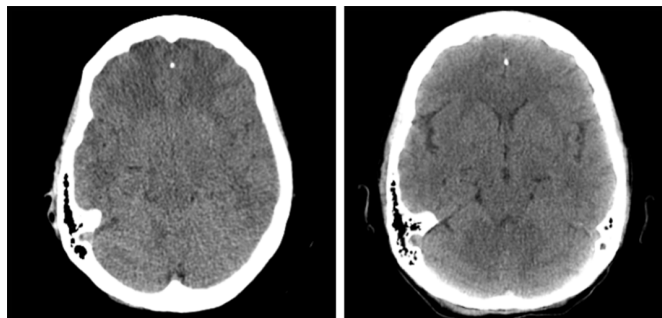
Axial CT at presentation (left) showing diffuse cerebral oedema with flattened gyri, lack of sulci, indistinguishable insula and collapsed cisterns. After resolution of metabolic derangement, the brain relaxed (right), and the patient recovered.
